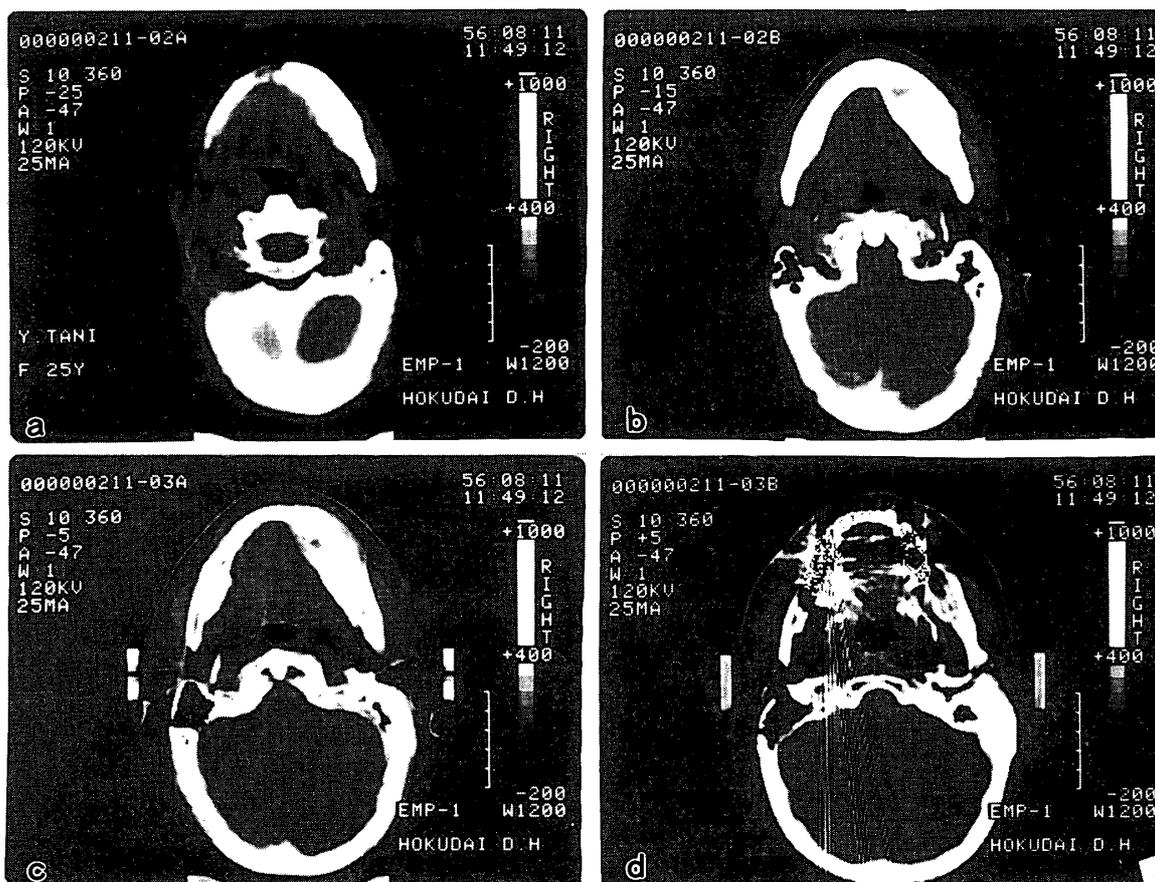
Coronal scan CT images show, as well as in Fig. 2, an expansible bony lesion in the right mandible, and the thickened diploë in the right side of the skull.
